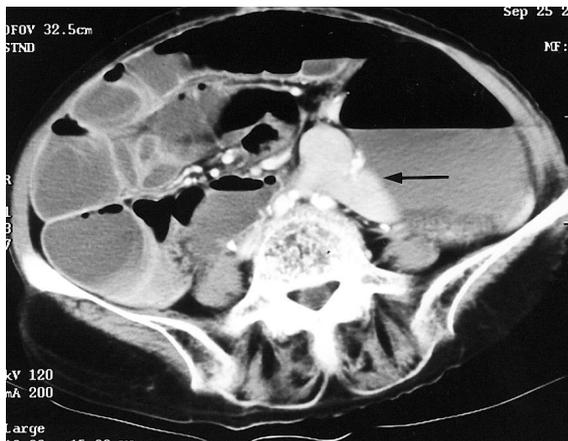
Abdominal CT showing the spleen (arrow) located at the inferomedial position of the stomach and abutting the calcified mass.
